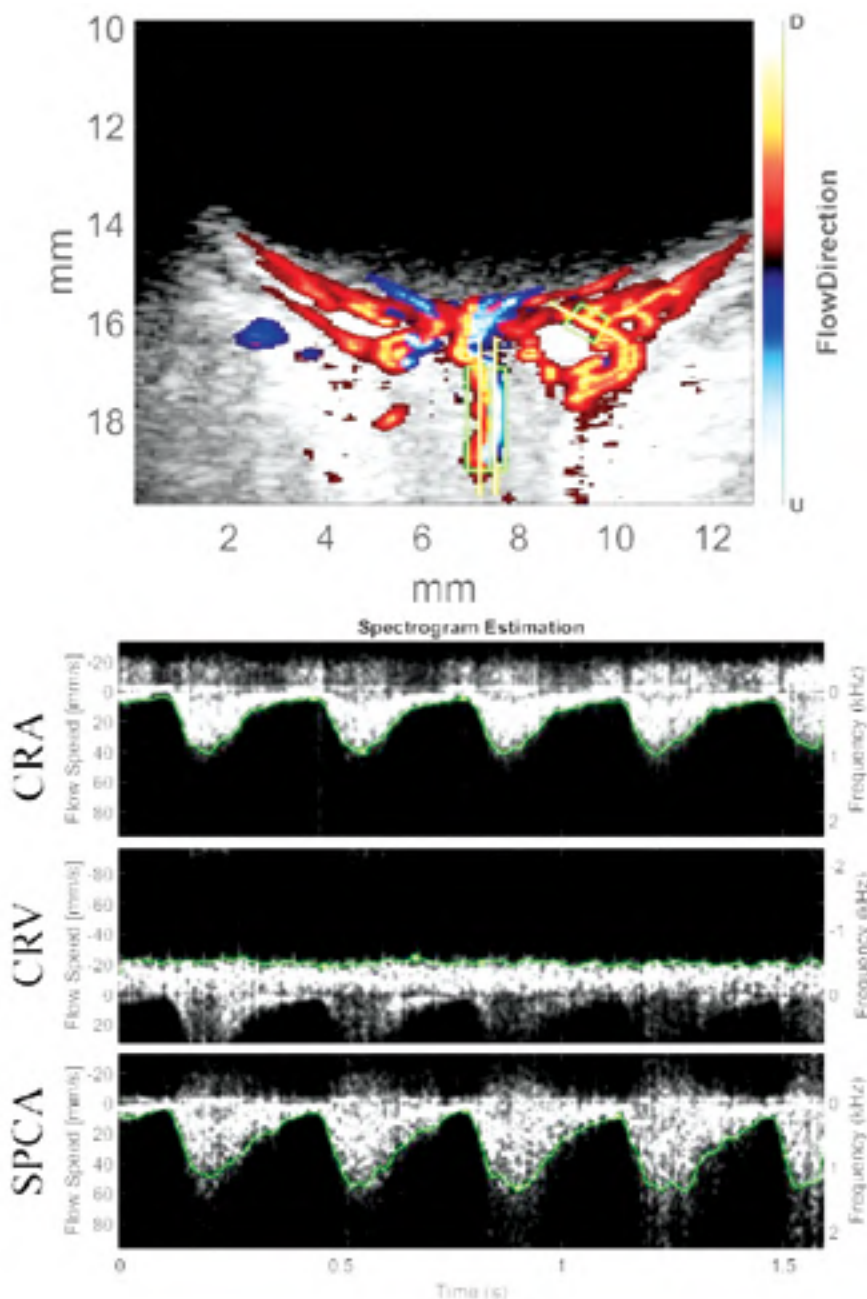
Plane-wave color-flow Doppler image of flow in the central retinal artery (CRA) and vein (CRV) and a short posterior ciliary artery (SPCA) of a preterm, low-birthweight neonate. Spectrograms depict pulsatile flow over 1.5 seconds.
